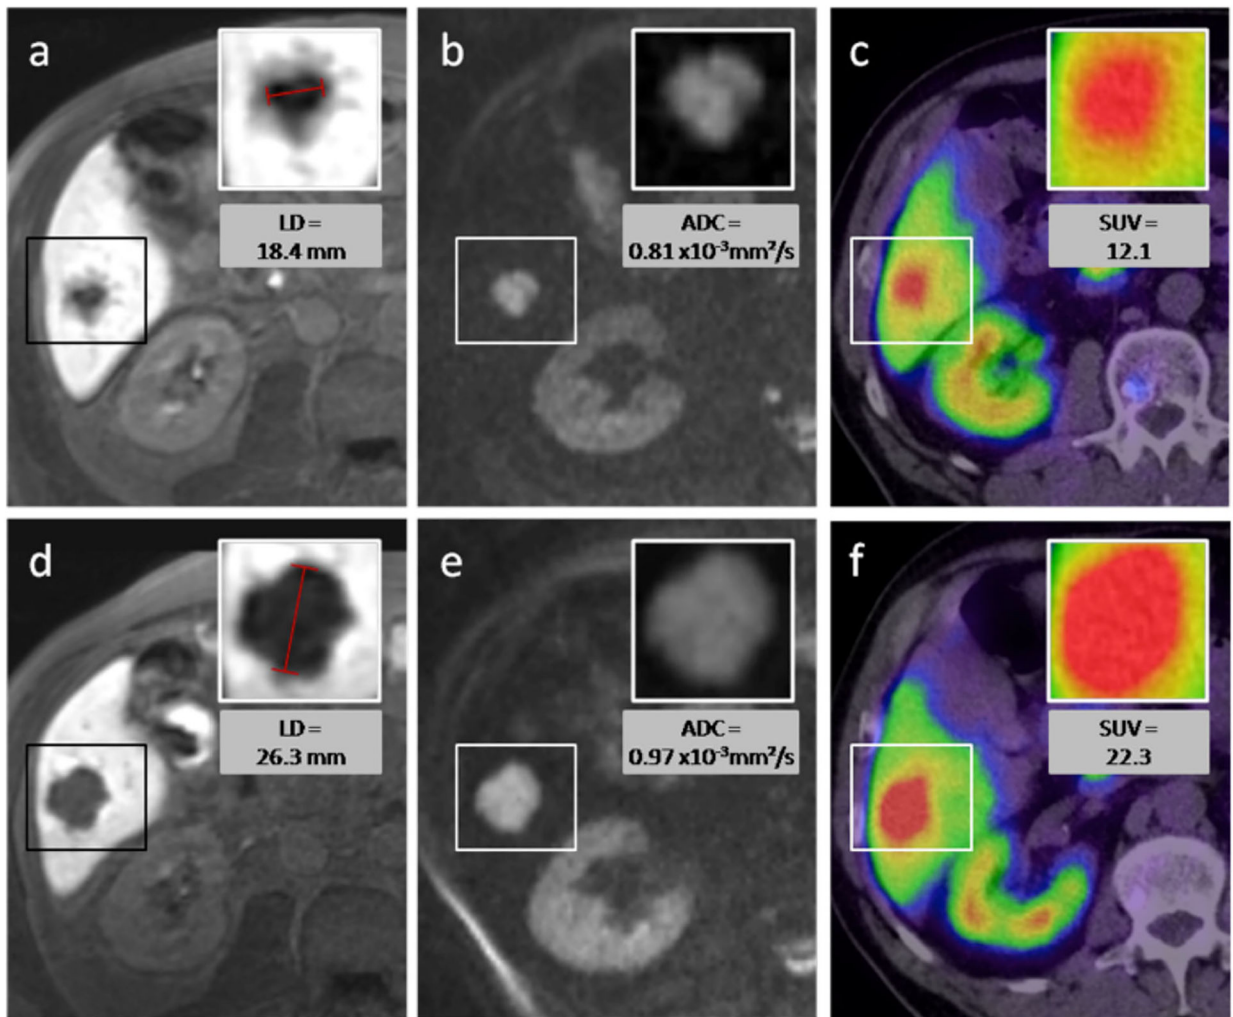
Nonresponding lesion—a 65-year-old male patient with caecal NET and hepatic metastasis. After one cycle of intraarterial PRRT with 4 GBq ^{90}Y - and ^{177}Lu -DOTATOC, the longest diameter of the target lesion (*box*) increased as seen on MR images with the hepatocyte-specific contrast agent (a, d). The volume of the lesion increased from 2.4 to 8.0 cm³. On diffusion-weighted MRI (b, e), an increase of ADC_{mean} from 0.81×10^{-3} to 0.97×10^{-3} mm²/s was measured, while the SUV_{max} in ^{68}Ga -DOTATOC-PET/CT increased from 12.1 to 22.3. *Upper row of figures* images before PRRT, *lower row* images after PRRT.
